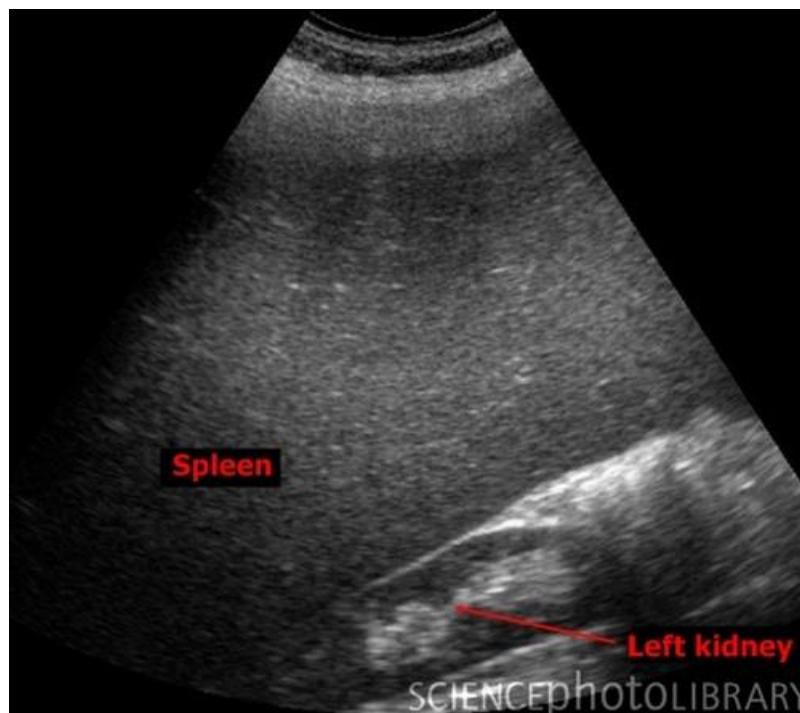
shows splenomegaly(www.stefajir.cz/?q=spleen-sonography)
